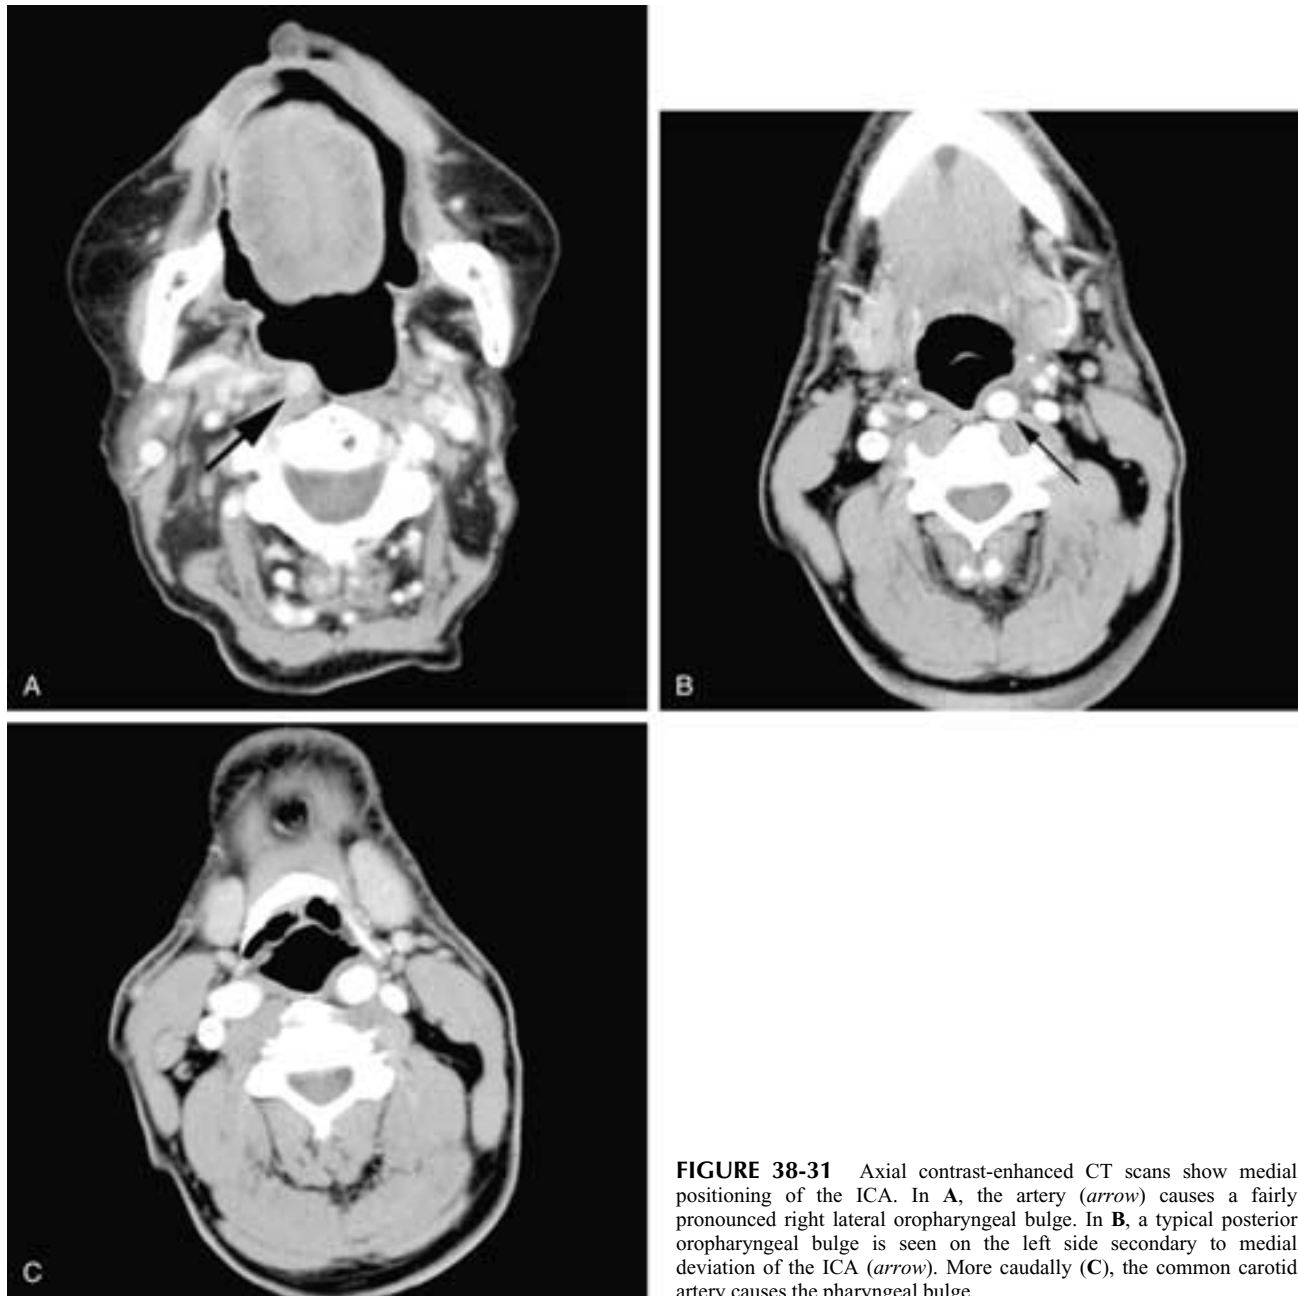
Axial contrast-enhanced CT scans show medial positioning of the ICA. In A, the artery (*arrow*) causes a fairly pronounced right lateral oropharyngeal bulge. In B, a typical posterior oropharyngeal bulge is seen on the left side secondary to medial deviation of the ICA (*arrow*). More caudally (C), the common carotid artery causes the pharyngeal bulge.
